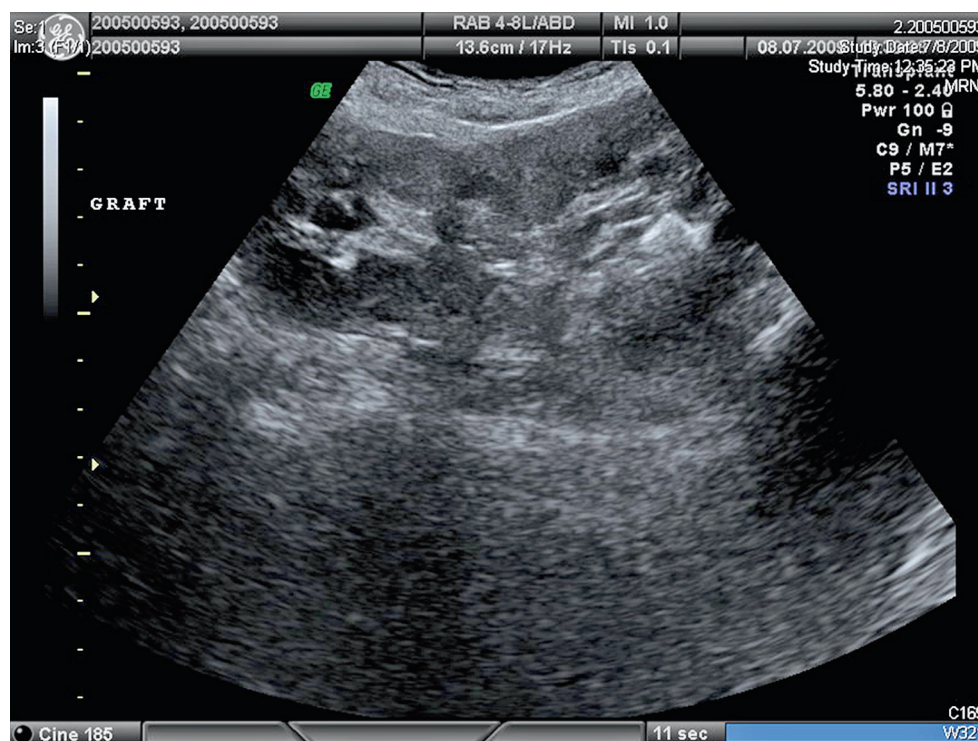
Gray scale ultrasonography shows a hyperechoic stone shadow with acoustic shadow behind a lower calyx
